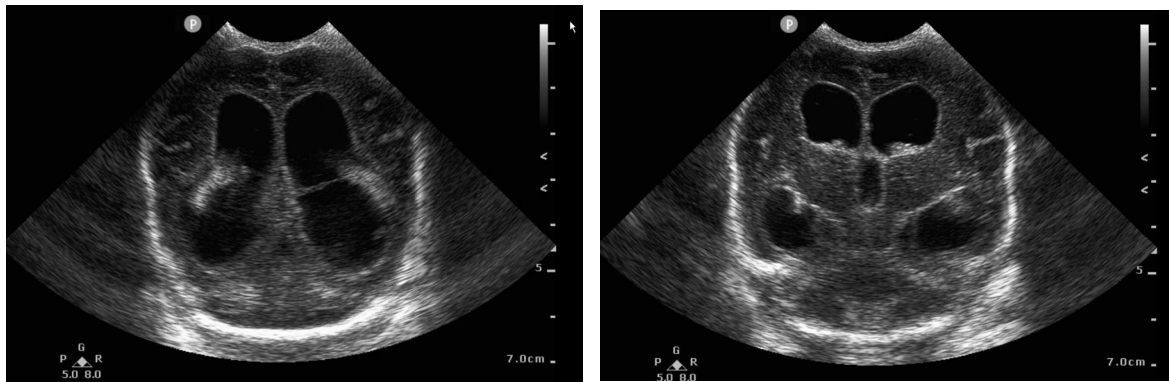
and 1C. Brain ultrasound made 11 days after the sepsis work-up, showing intraventricular septation, suggestive of ventriculitis. There is also dilatation of the lateral ventricle and third ventricle (Davies on the left side 13.7 mm, on the right side 13.9 mm (both compatible with severe ventriculomegaly), Levene index on the left side 16.2 mm ($>+2$ SD+4 mm), on the right side 14.4 mm ($>+2$ SD)).
